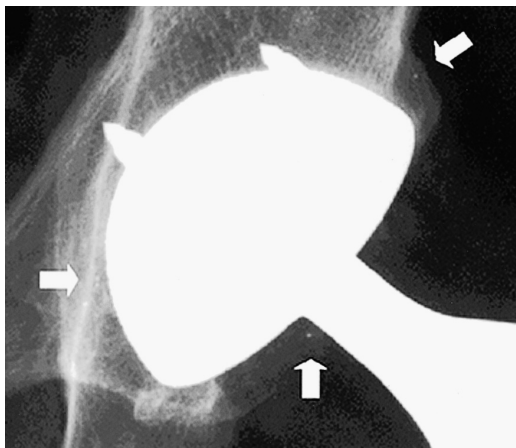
Postoperative radiograph shows 4 beads located in De Lee and Charnley areas 1 and 3, and 1 bead in the periarthicular soft tissues.
